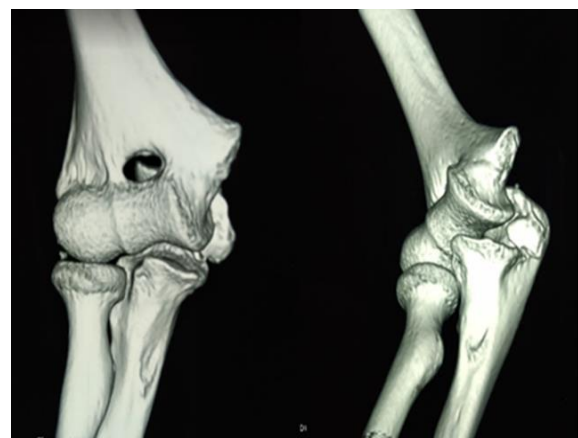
CT scan confirmed the avulsion fracture of medial epicondyle with opening up of medial humero ulnar joint space.
